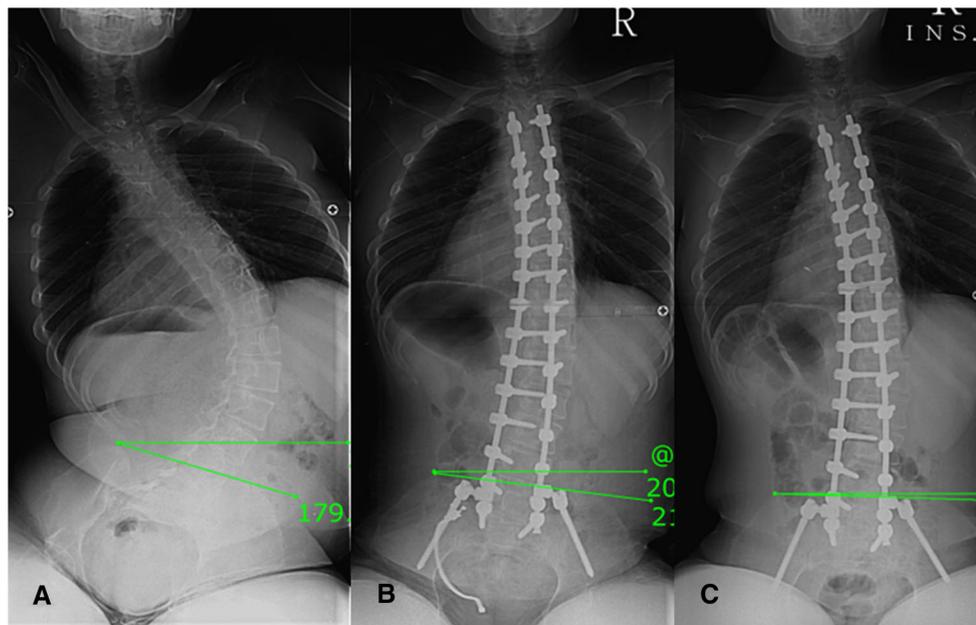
Radiological picture of a 17-years-old boy with DMD having scoliosis of 87° (a). He was operated with pedicle screw fixation with pelvic fixation by HMSP connector. Postoperative X-ray (b) showed
